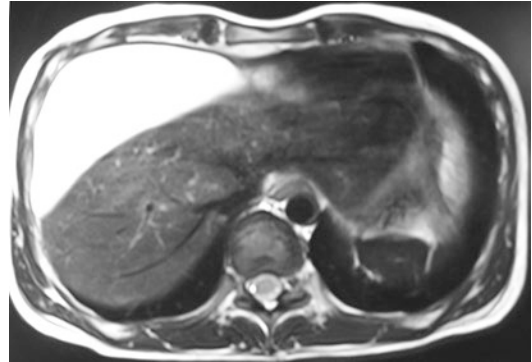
Magnetic resonance imaging shows biloma
